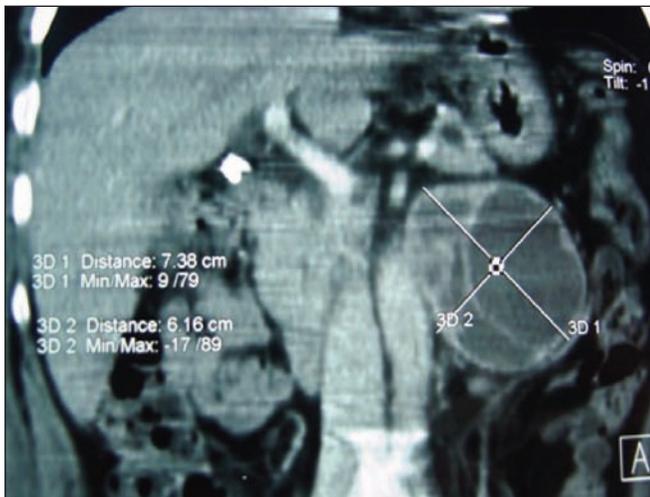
An abdominal computed tomography scan in the transverse plane shows a round mass that is heterogeneously dense and well-defined, touching both the aorta and left kidney pedicle.
